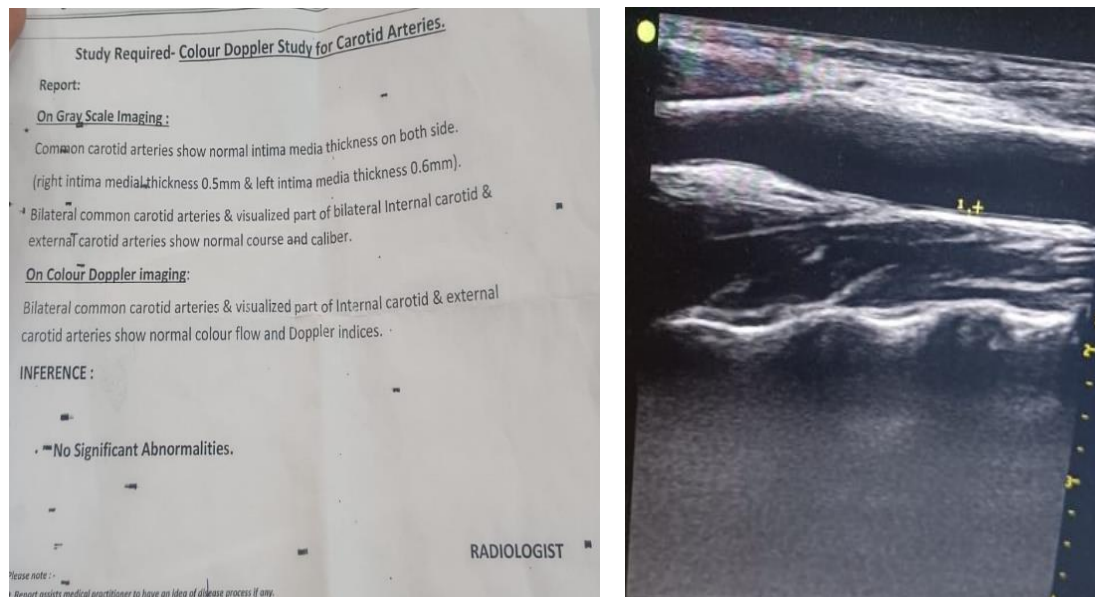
Carotid artery doppler for measuring CIMT.
